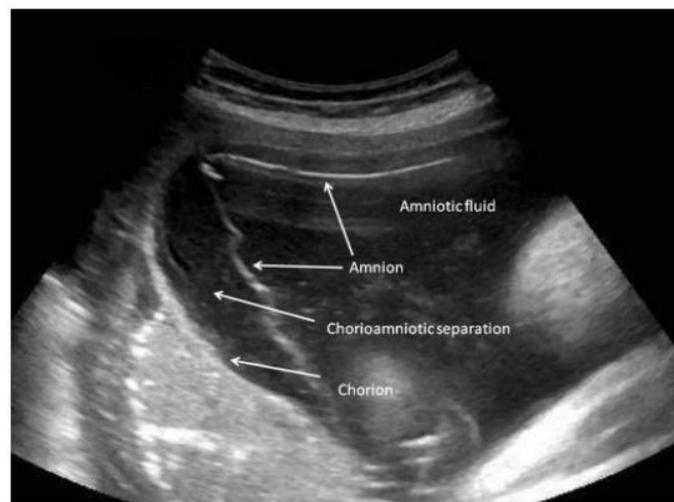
Chorioamniotic separation diagnosed by ultrasound evaluation at 39 weeks. The arrows point at the amniotic membrane that has separated from the chorion. (30)
